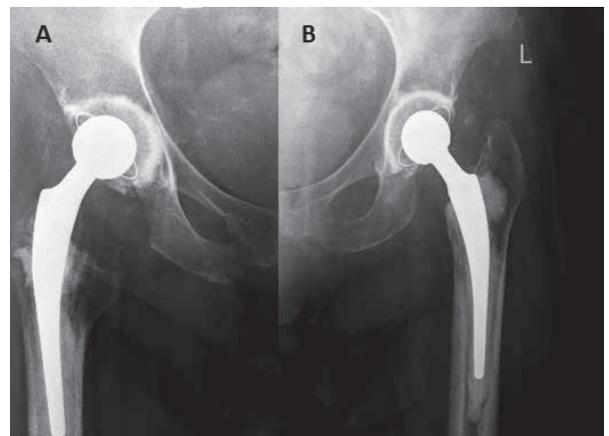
Pelvic X-ray- cemented total right (A) and left (B) hip prosthesis
